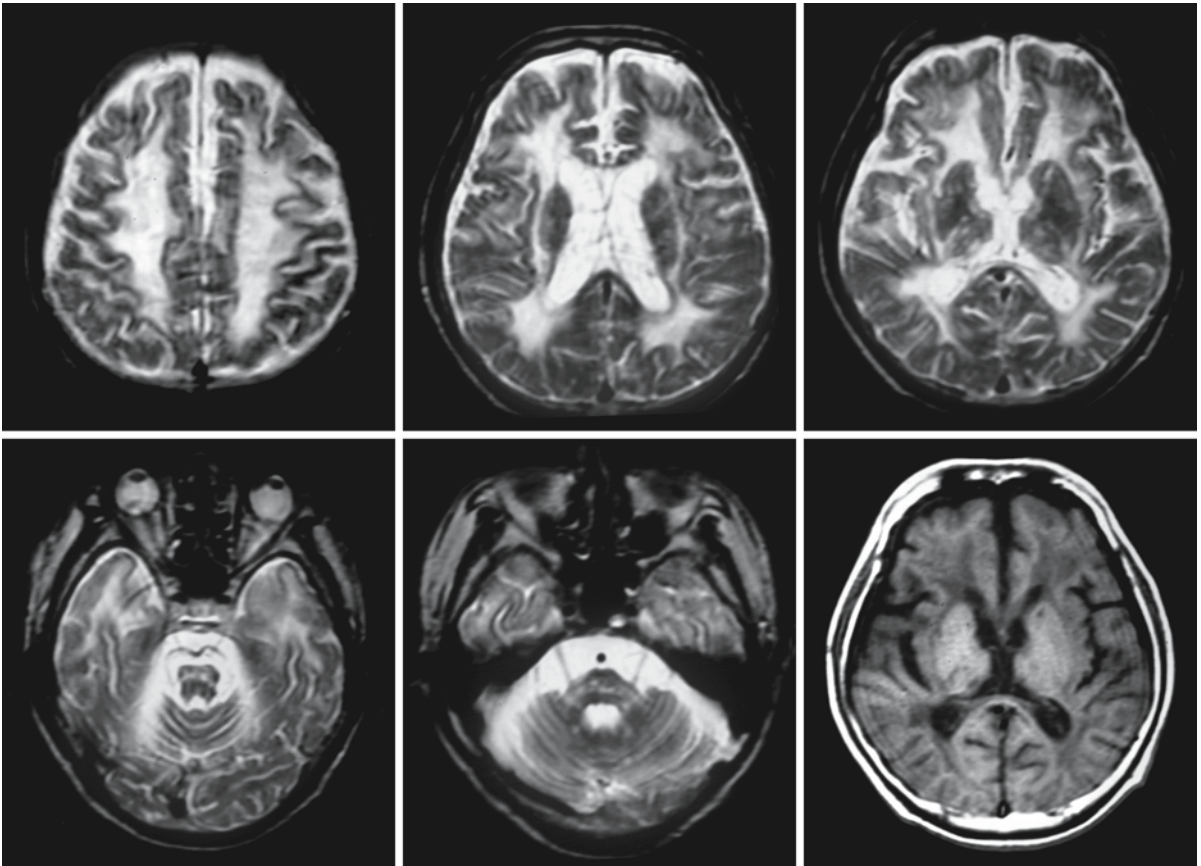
A 42-year-old male patient with CARASIL. The MRI was obtained 16 years after the onset of the disease. Note the extensive cerebral white matter abnormalities, which do not spare the U fibers. The internal and external capsules are affected as well. The cerebral white matter is atrophic; the corpus
